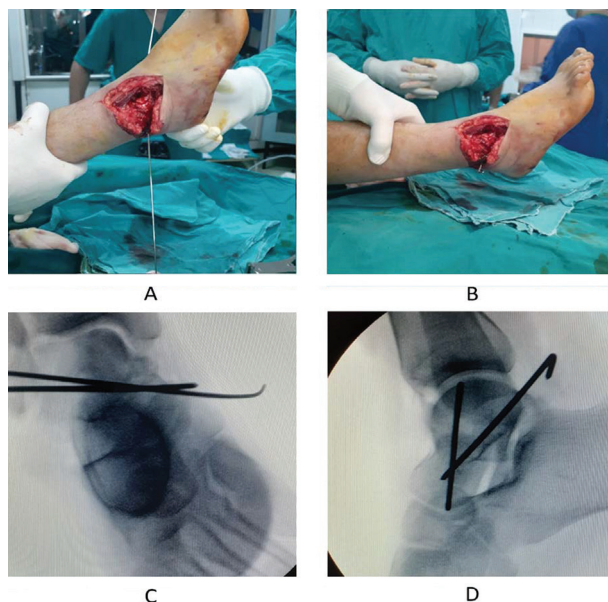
Minimally percutaneous osteosynthesis of the talus with two Kirschner wires. A and B - Intraoperative look (shew), C - Anterior Posterior (AP) dorsoplantar radiograph view and D - lateral radiograph view
